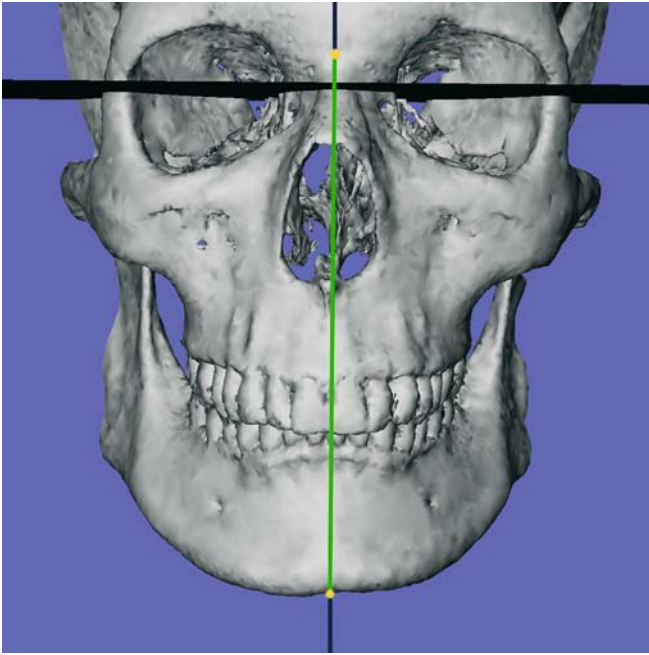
The frontal inclination of the facial midplane from the median (z) 3-D cephalometric reference plane is a projected angular measurement on the vertical (y) 3-D cephalometric reference plane (3-D CT, hard tissues, patient K.C.)
